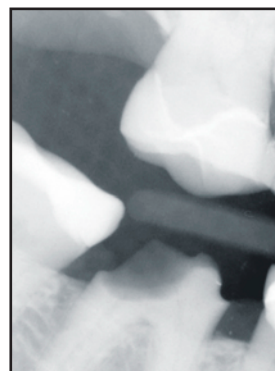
Preoperative radiograph shows the initial measurement from the restorative margin to the bony crest is approximately 1 mm.
